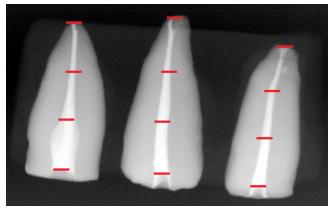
Digital radiograph divided by thirds at mesialdistal direction
